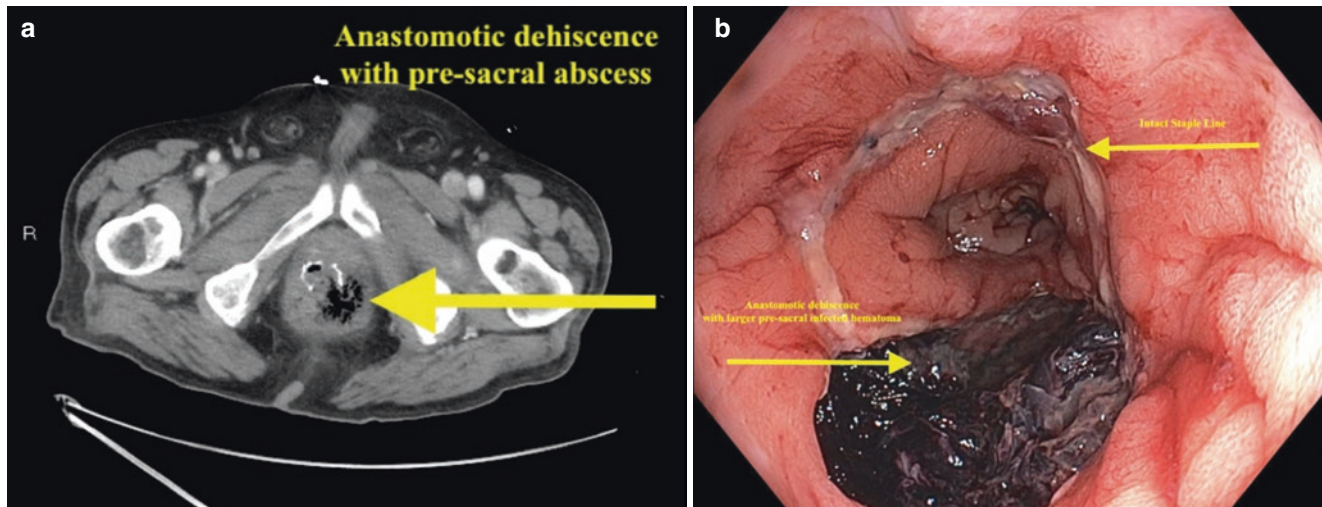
(a) CT scan of patient presenting with an anastomotic bleed on POD 9 showing a pelvic abscess and anastomotic dehiscence. (b) Endoscopic exam confirming anastomotic dehiscence with pelvic hematoma
